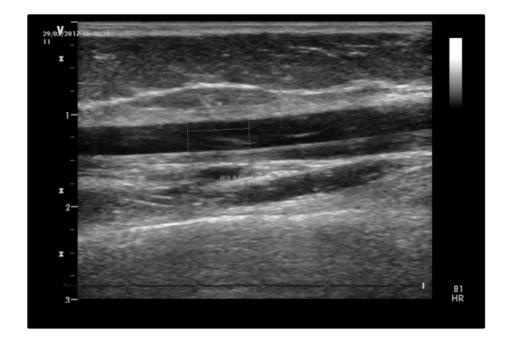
Example B-mode ultrasound image of the brachial artery for the analysis of diameter and subsequently FMD %.
